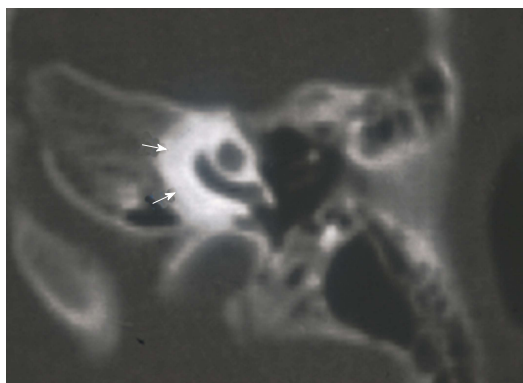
CT appearance of cochlear otosclerosis. Note for perilyabyrinthine decalcification (marked with arrows).
